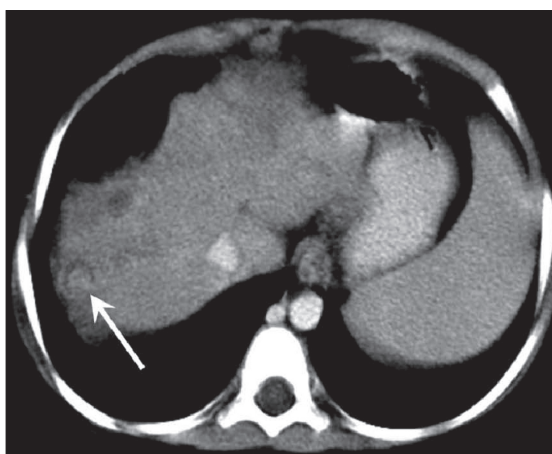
Transverse contrast enhanced CT demonstrated focal hypodense hepatic lesion in segment #7 with focal central enhancement (nodule-in-nodule) represents hepatocellular carcinoma within a dysplastic nodule (arrow).
